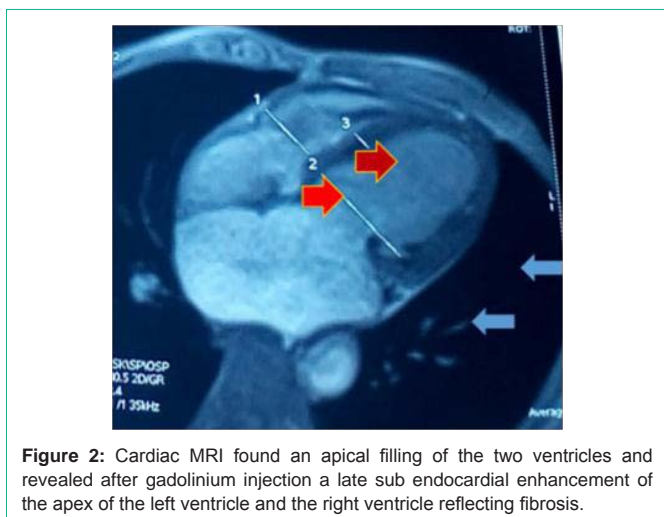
Cardiac MRI found an apical filling of the two ventricles and revealed after gadolinium injection a late sub endocardial enhancement of the apex of the left ventricle and the right ventricle reflecting fibrosis.
